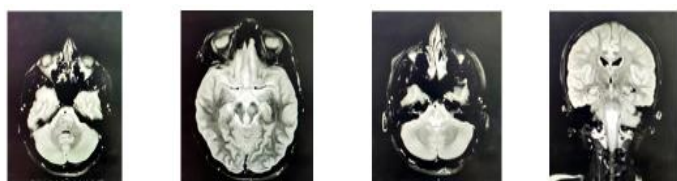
Second MRI showing T2 hyperintensities bilaterally symmetrical in pons with extension in medulla, peri-aqueductal area, mid brain, hypothalamus and subthalamus areas, suggestive of brain stem encephalitis
